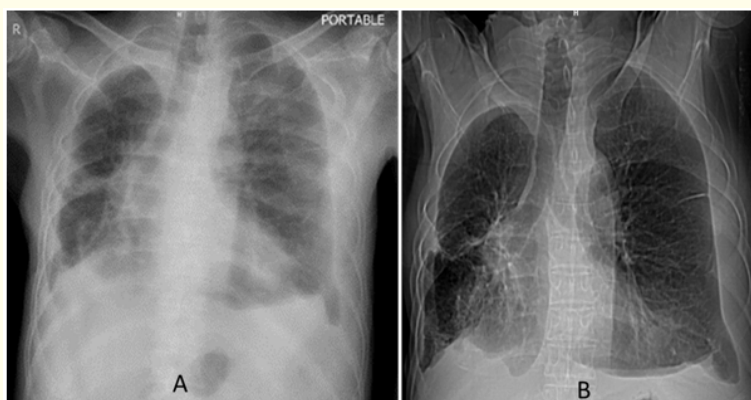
X-ray chest showing bilateral pleural effusion, bronchiectasis, and pleural thickening. There is volume loss on the right side.
